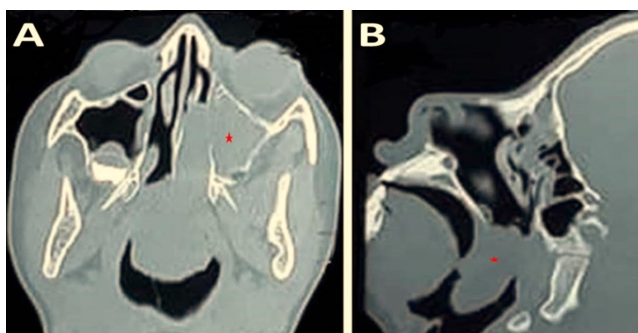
CT scan of the nose and paranasal sinuses. A: Axial view shows a hypo-attenuating lesion (red Asterix) occupying the left maxillary sinus and extending through the nose to the nasopharynx. B: Sagittal section revealed the hypo-attenuating lesion in the nasopharynx and oropharynx (red Asterix).
